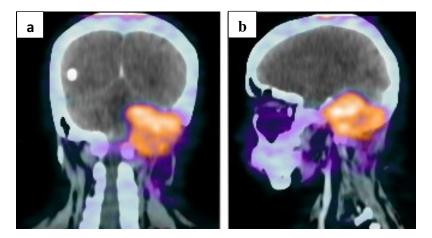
Ga-68 labeled DOTATATE PET/CT scan (a) Fused coronal image shows avid mass. Occupying the left cerebellar hemisphere and infiltrating basiocciput (b) Fused sagittal image shows avidity in the same area.
